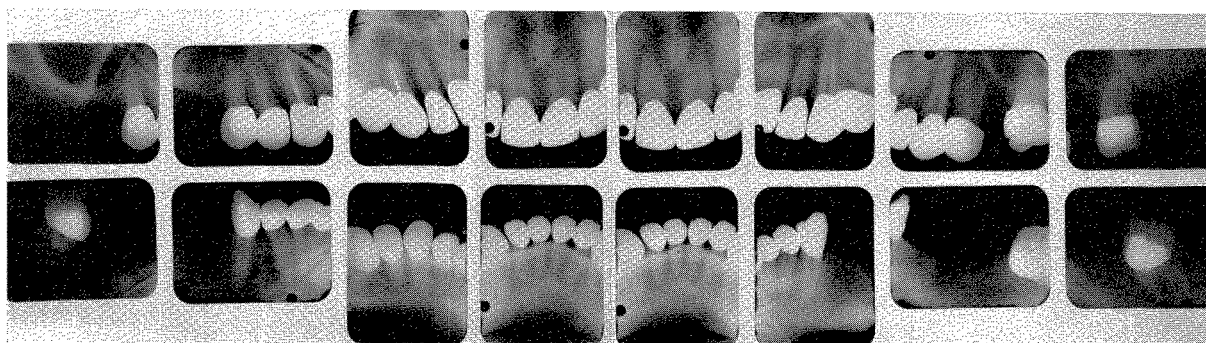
Roentgenograms of the completed work. These were taken in March, 1945.
